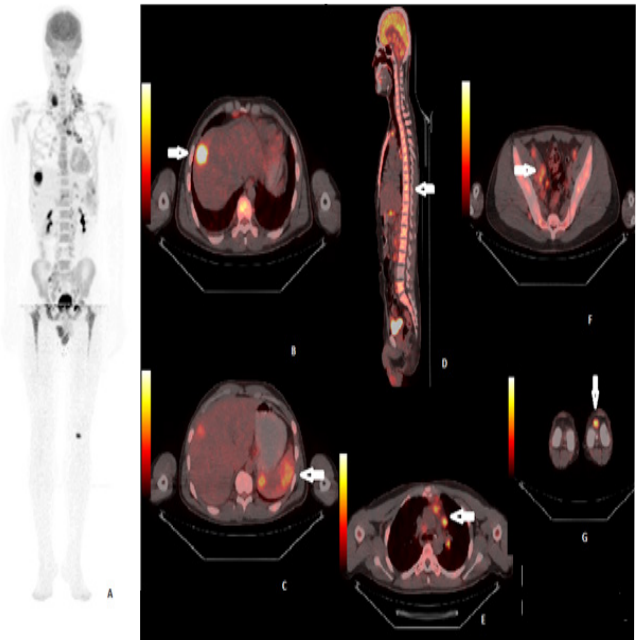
The whole-body PET/CT: A) Maximum intensity projection (MIP) images, B) liver lesion, C) splenic lesion, D) vertebral column uptake, E) mediastinal lymph node involvement, F) pelvic lymph nodes, G) focal patellar uptake (white arrows).
